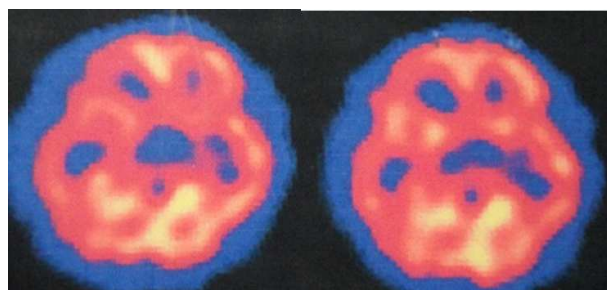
A, B After treatment, interictal SPECT shows that cerebral perfusion was restored to normal
